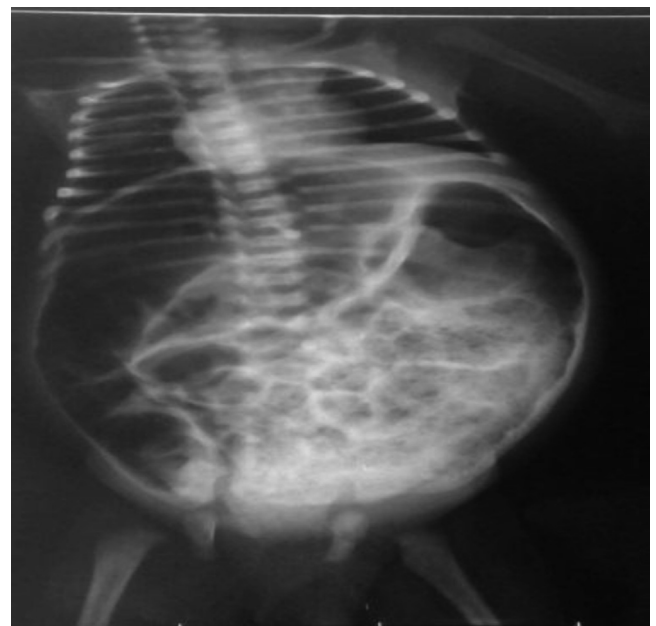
Supine abdominal X-ray (with oral contrast) showing grossly distended colon.
